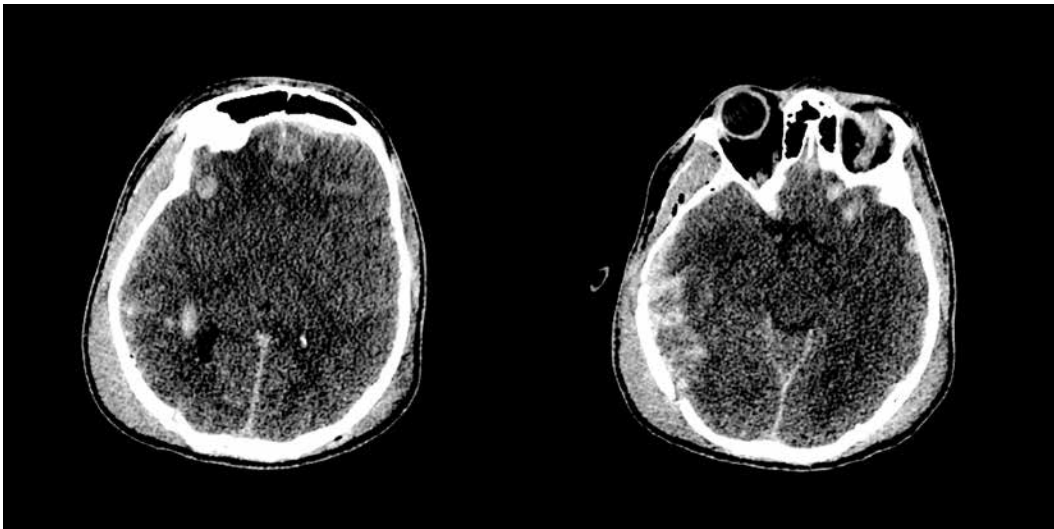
and 1B. CT of the head on admission to hospital performed with a 64-slice CT Revolution EVO GE MEDICAL SYSTEMS, 120 kV, 160 mA, images on the transverse plane, slice thickness 0.625 mm. Visible are numerous midbrain haematomas of the right brain hemisphere, subdural haematoma along the right brain hemisphere and along the left frontal lobe as well as blood in the brain fissures evidence of subarachnoid bleeding. Also visible are numerous cranial bones fractures. Intracranial gas bubbles on the border of the right temporal and occipital lobe.
